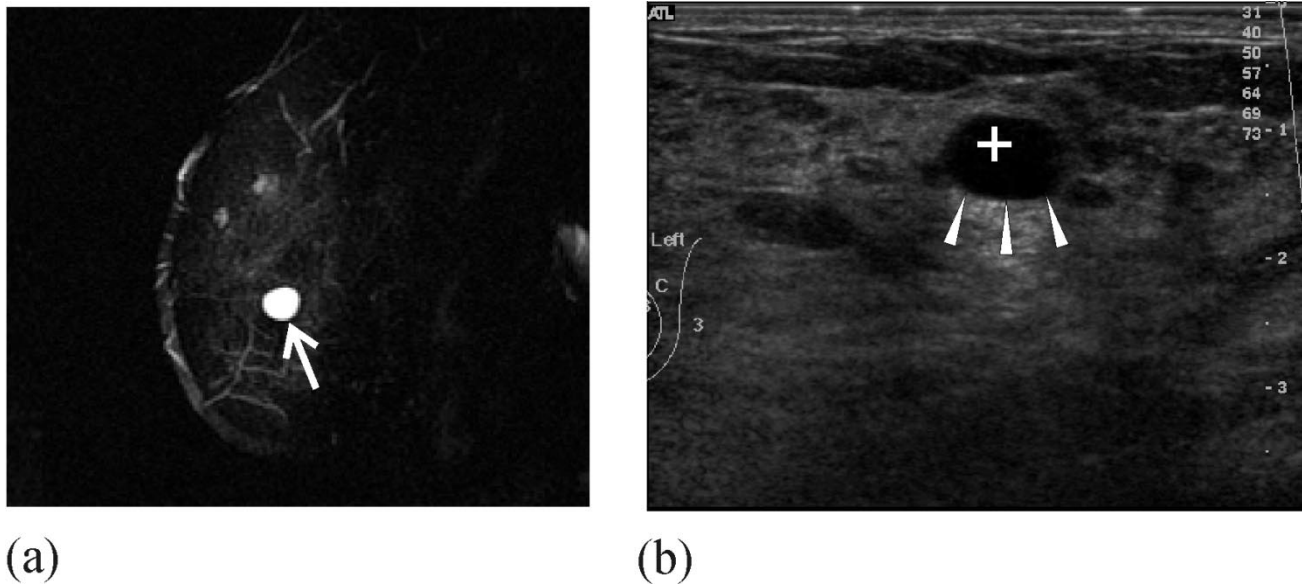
Clinical application of MR-US co-registration of a cyst (a) 1.0-cm cyst identified with T2-weighted MRI sequence (arrow). (b) Co-registered US image depicting 1.0-cm lesion at a position 2.7 mm from the predicted MRI position (cursor). Registration error was determined to be (X , Y , and Z) 1.5, 1.0, and 2.0 mm.
